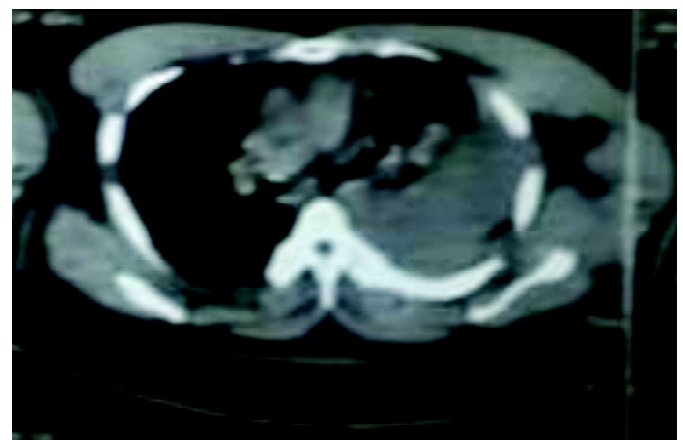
CT Thorax showing left hemothorax
